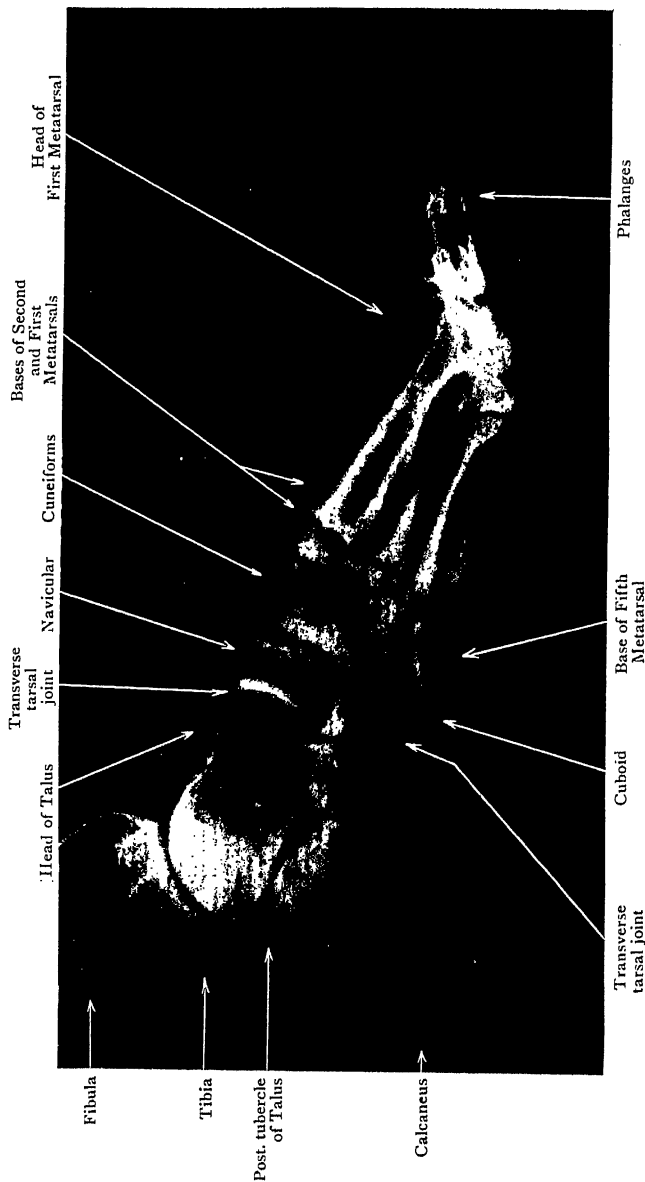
Lateral Radiograph of Foot of girl aged 17.
